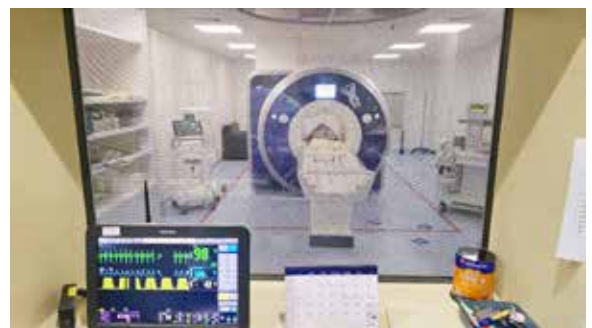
Second monitoring unit in MRI control room
